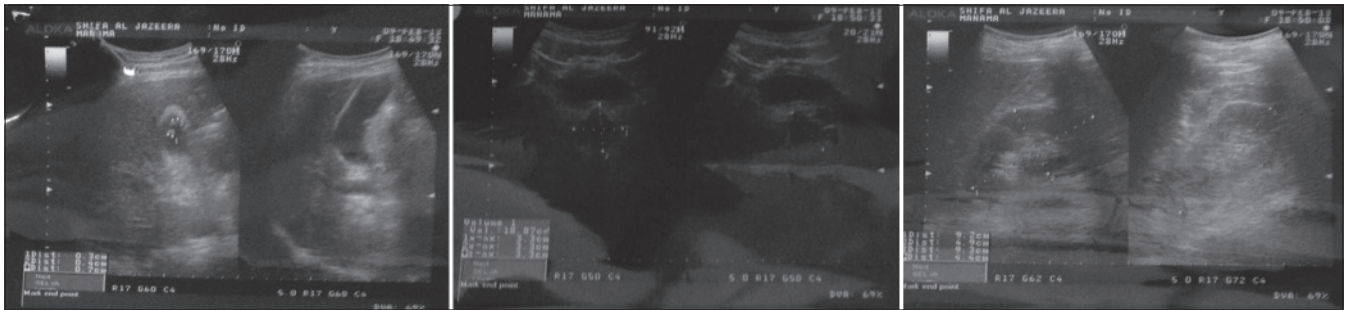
Ultrasound Images
